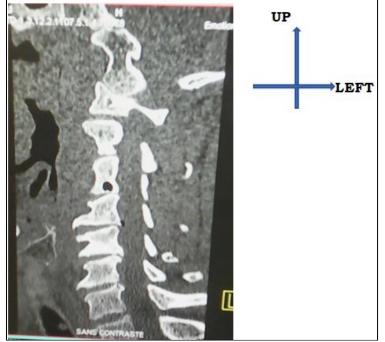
CT of the cervical spine (sagittal reconstruction)
